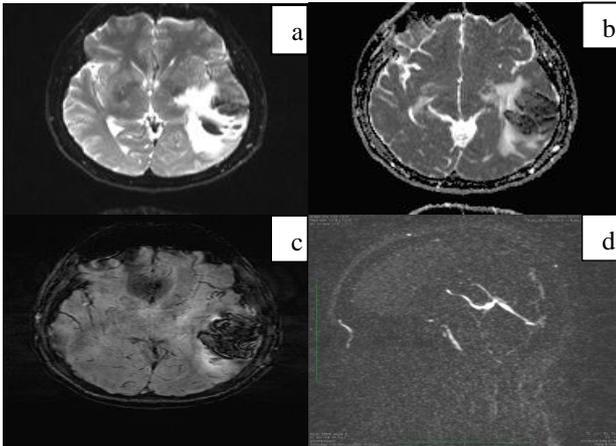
DWI and ADC images showing infarct in left temporo-parietal regions; (c):SWI showing blooming within the area of infarct confirming it to be a hemorrhagic infarct; (d) Sagittal 2D TOF image showed absence of flow signals in superior sagittal sinus, transverse sinus and sigmoid sinus.
